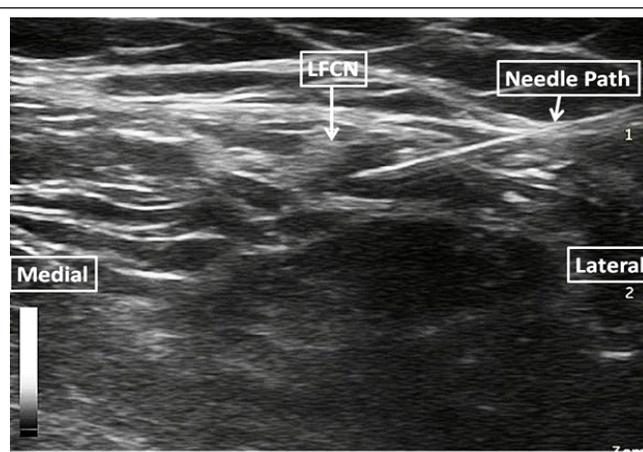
Sonographic image showing the needle path and needle placement adjacent the LFCN.
